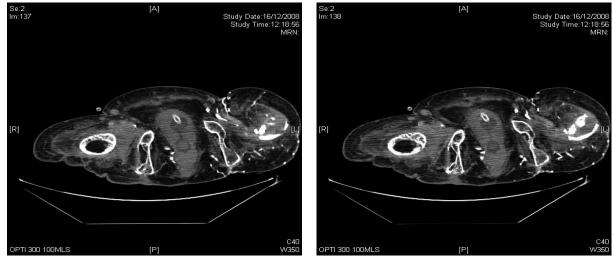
Axial section of computed tomography of pelvis showed inflammatory granulation tissue in right hip; there was old dislocation and resorption of right femoral head. In the left hip, there was an abscess. Again there was resorption and lysis of the femoral head. An incidental finding was hourglass deformity of urinary bladder. Suprapubic catheter was located in the anterosuperior compartment of the hourglass bladder.
